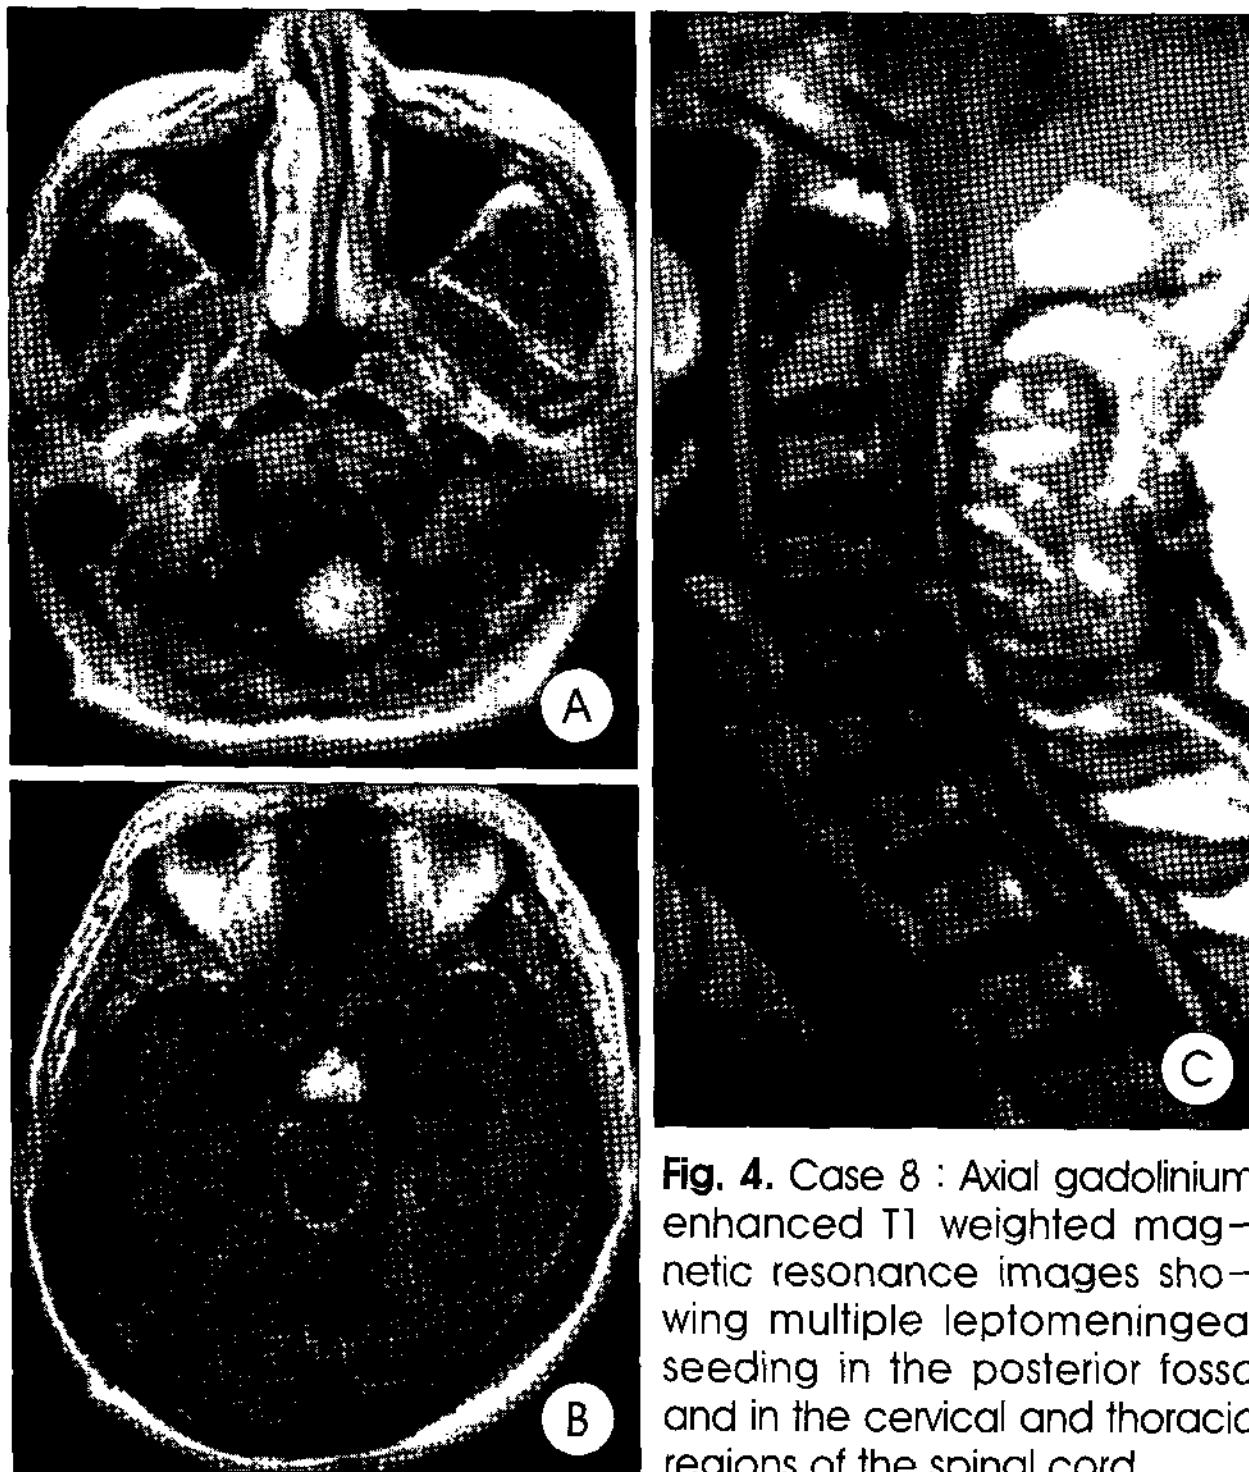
Case 8 : Axial gadolinium enhanced T1 weighted magnetic resonance images showing multiple leptomeningeal seeding in the posterior fossa and in the cervical and thoracic regions of the spinal cord.
